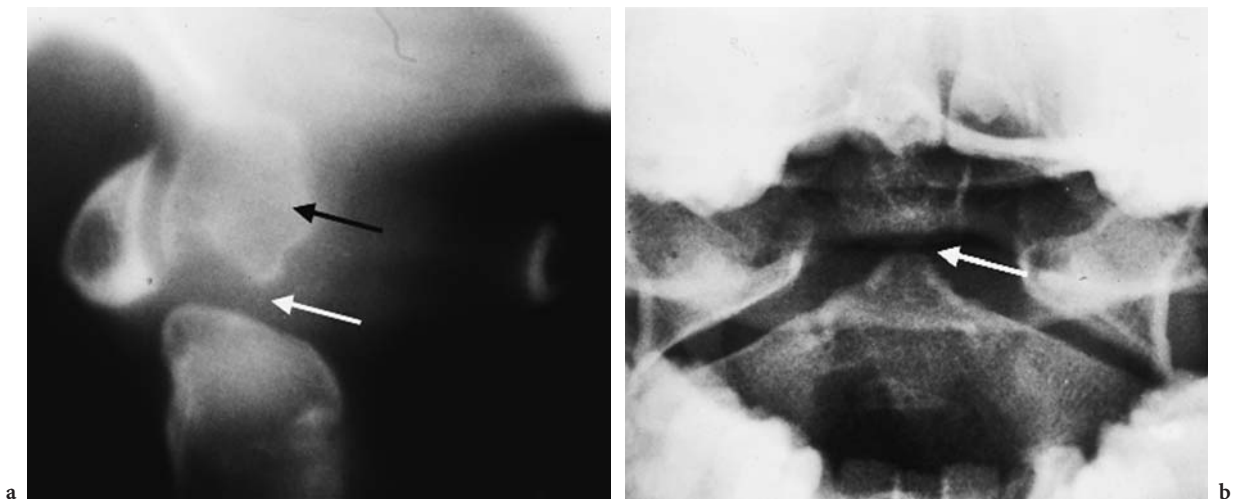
Os odontoideum. Lateral view radiograph. Terminal ossification of dens (os odontoideum) (*black arrow*), non-ossified cartilage (*white arrows*), and body of the dens
